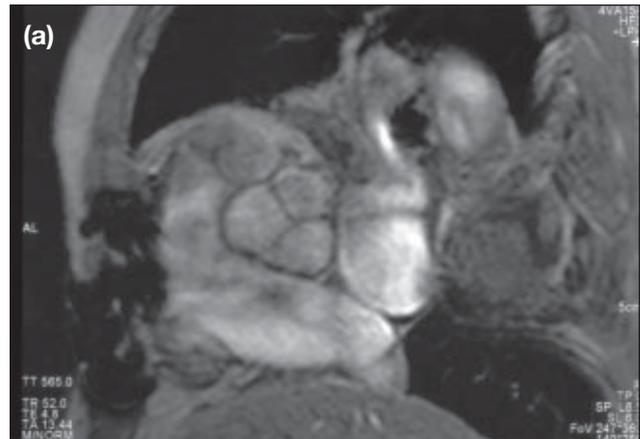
Magnetic resonance images (a) showing the closure of the tricuspid and aortic valves; (b) showing the opening of the tricuspid and aortic valves; (c) with left ventricular outflow view showing mild regurgitation of the aortic valve (arrow)
